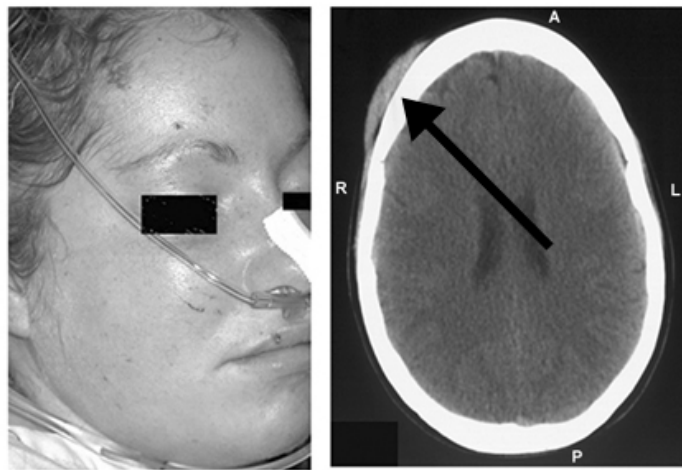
Crash occupant photograph shows only minor abrasions on skin of right forehead. Transverse CT scan image at the level of the forehead shows a sizable hematoma and soft tissue contusion on the right forehead.
